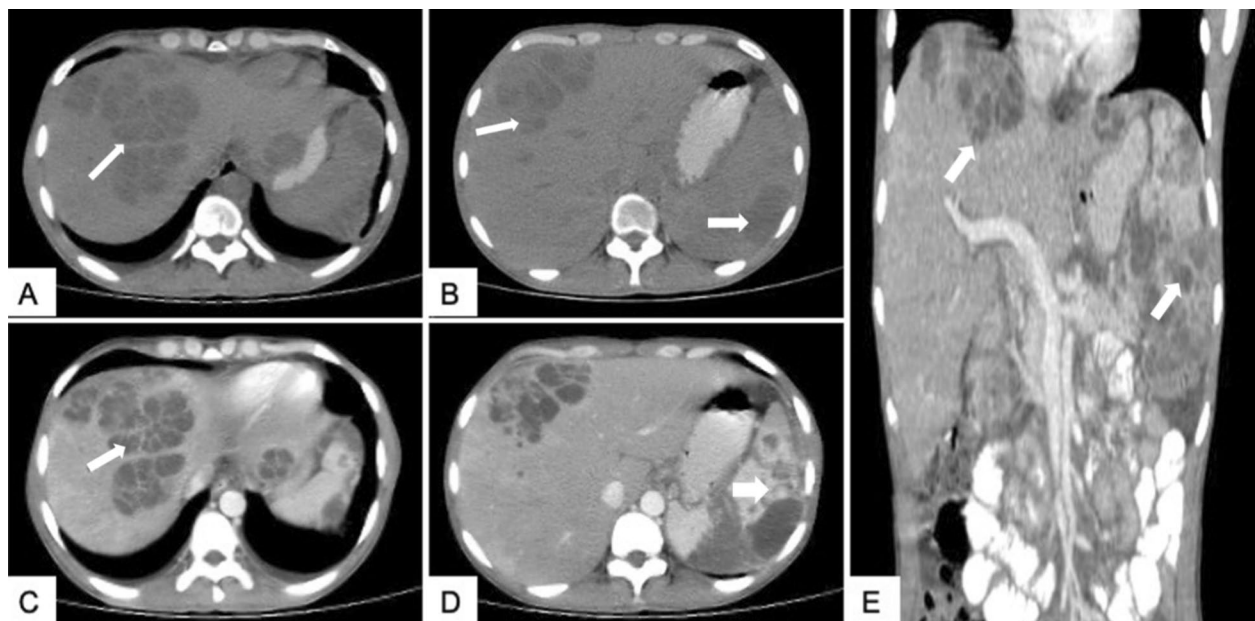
CT abdomen-Plain A, B and contrast-enhanced C, D axial and coronal E images showing multiple hypodense lesions in the liver and spleen (arrow) with enhancing internal septations giving a "honeycomb" appearance (arrow)
